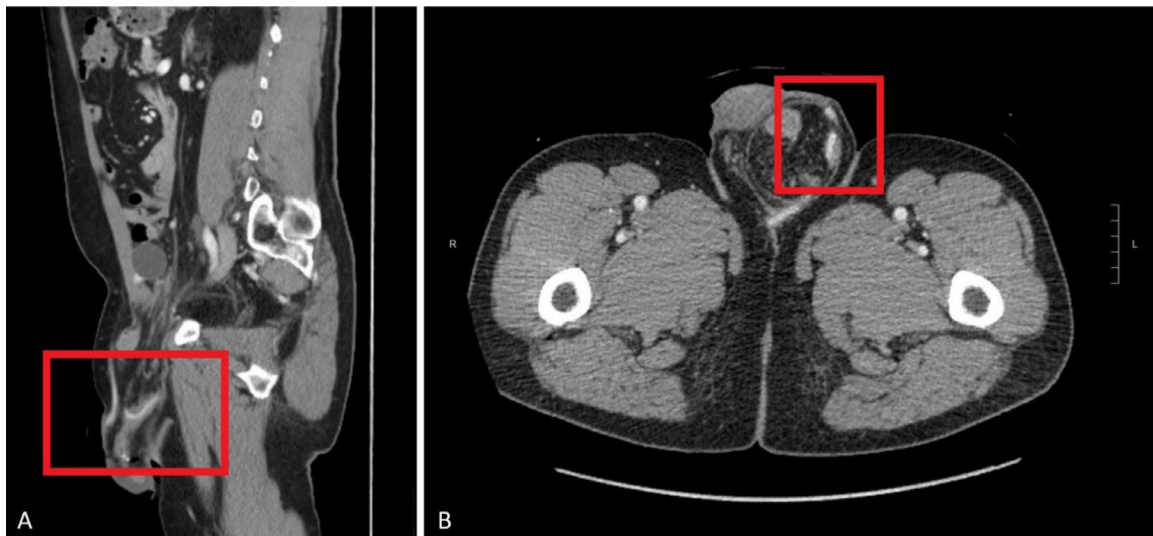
CT images of left inguinal hernia; (A) sagittal plane; (B) coronal plane.
